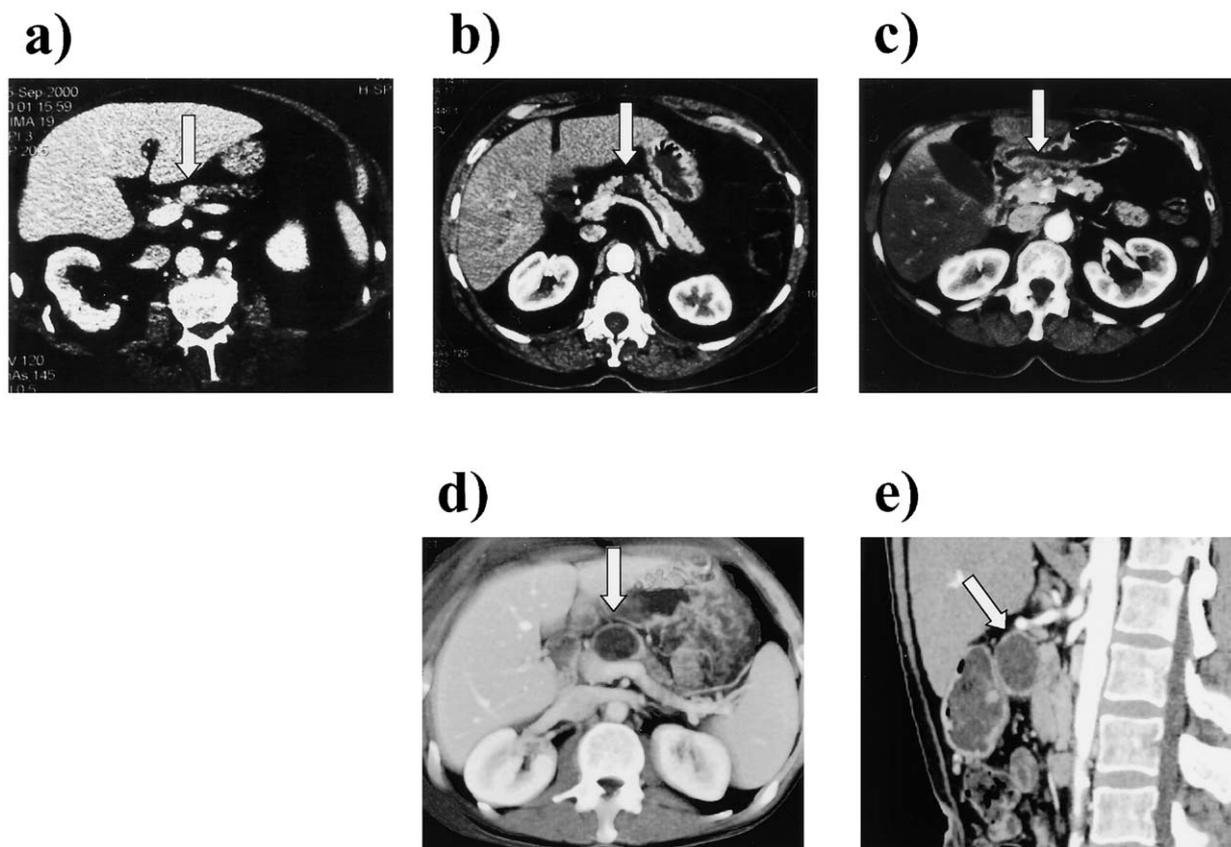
CT scans demonstrating lesions resected via central pancreatectomy. (A) Hypervascular lesion in the neck of the pancreas; pathology: islet cell tumor. (B) Cystic lesion in the mid-body with dilated distal duct; pathology: IPMN. (C) Cystic lesion in the neck of the pancreas; pathology: serous cystadenoma. (D) axial and (E) coronal of a three-dimensional reconstruction CT scan of a cystic lesion of the pancreatic neck; pathology: simple cyst (*arrows* demonstrate lesions).
